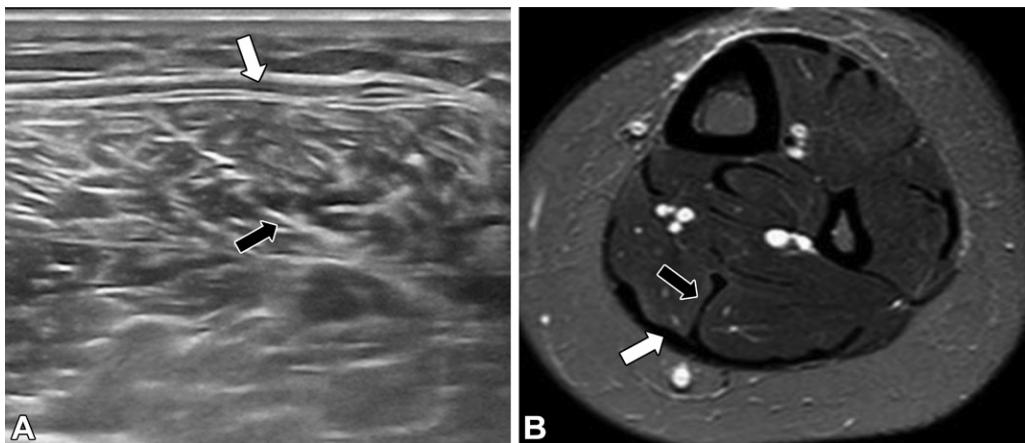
Anatomy of the distal one-third of the leg. US image (A) and axial proton-density–weighted fat-saturated MR image (B) show the distal one-third of the soleus muscle with its CIT (black arrow) contributing to the formation of the Achilles tendon (white arrow).
